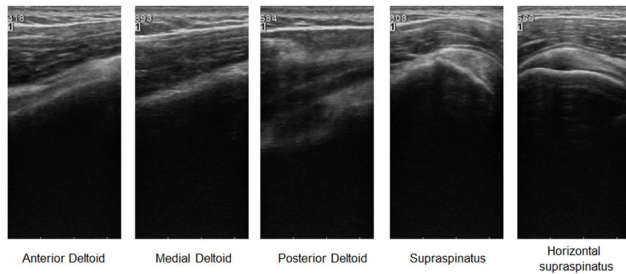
B-mode ultrasound images correspond to the five distinct areas of the shoulder structure of Figure 1.
